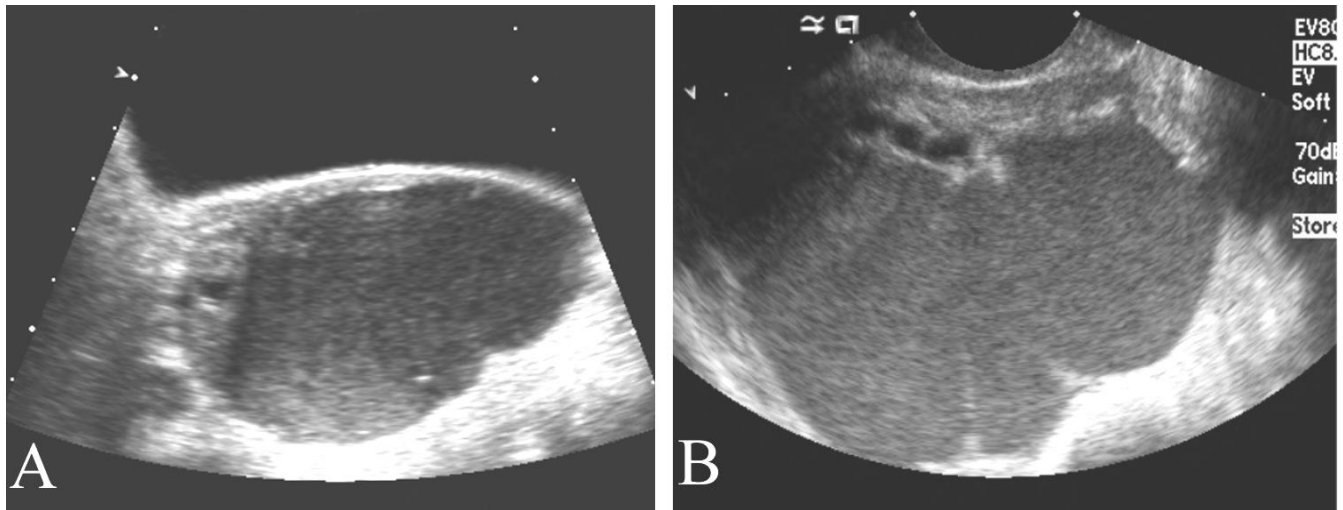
Endometriosis in a 32 year old with pelvic pain. A. Transabdominal ultrasound shows a large homogeneous pelvic mass. B. Transvaginal ultrasound also shows a large homogenous mass with somewhat better detail of the uniform coarse echotexture. Imaging features are characteristic of an endometrioma (as was found at surgery), but some hemorrhagic cysts have a similar appearance.
